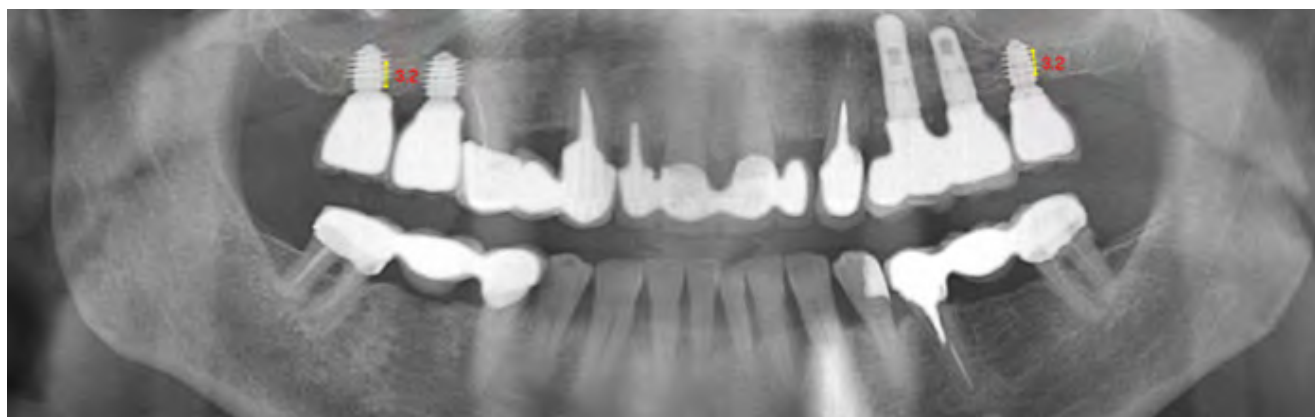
Three years follow up panoramic X-ray showing a successful rehabilitation using short implants engaged only 3-4 mm in the residual bone under the sinus.
